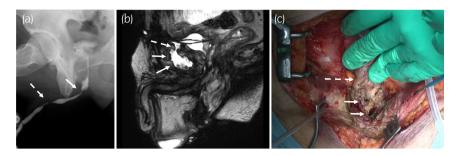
Radiological and operative findings of case 1. (a) Retrograde urethrography showed synchronous urethral stenosis at the penobulbar urethra (dotted arrow) and the bulbomembronous junction (arrow). (b) T2-weighted MRI in the sagittal plane showed a USF from the SPT tract (dotted arrow) to the pubic symphysis (arrows). (c) Intraoperative finding of USF arising from the SPT tract (dotted arrow) to the pubic symphysis (arrows).
